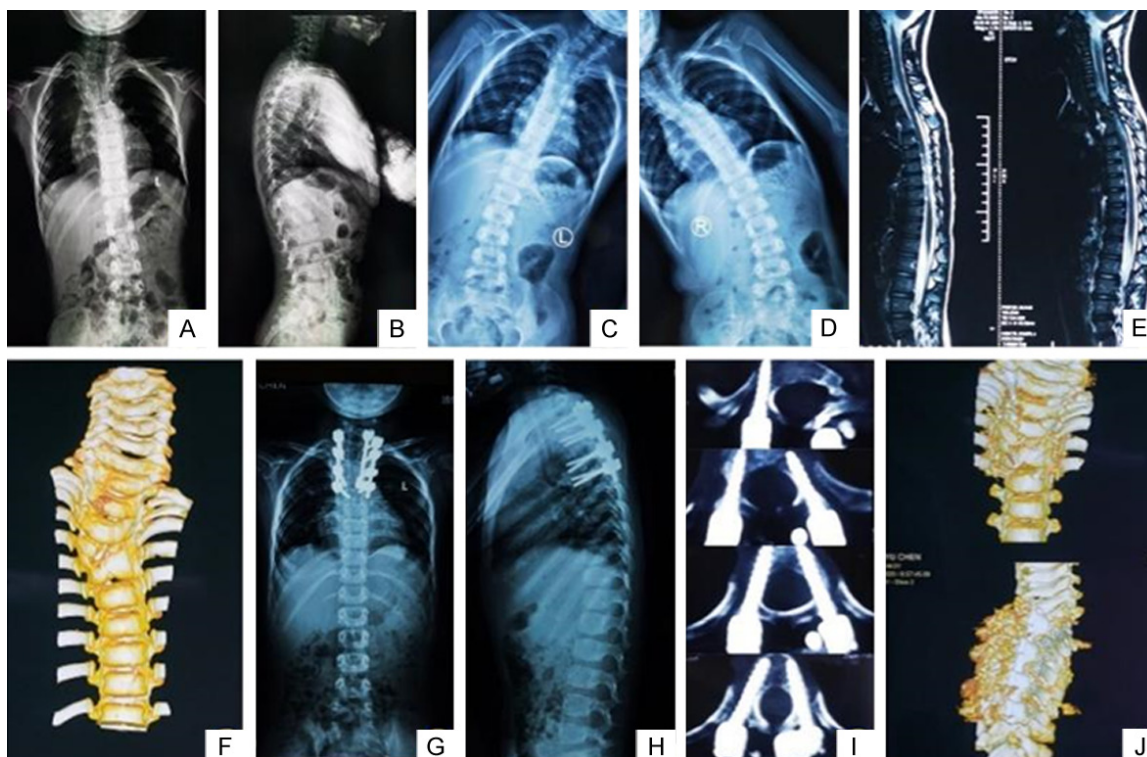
Typical case. Male, 10 years old, with congenital scoliosis. A-D. The patient presented with a thoracic hemivertebra spinal deformity. E. Preoperative MRI suggests hemivertebra deformity. F. CT suggests thoracic hemivertebra deformity. G, H. Postoperative frontal and lateral DR. I, J. Postoperative CT. The patient recovered well with no significant complications.
